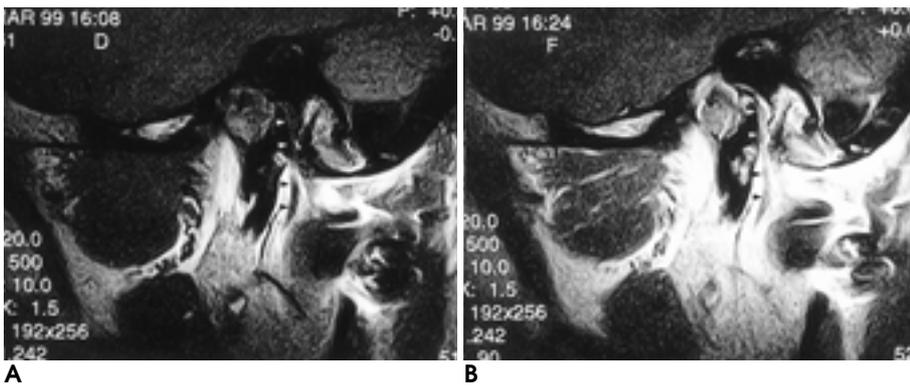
33-year-old woman with post-traumatic the Rt. facial palsy. MR images were obtained 1 week after onset of symptoms.
